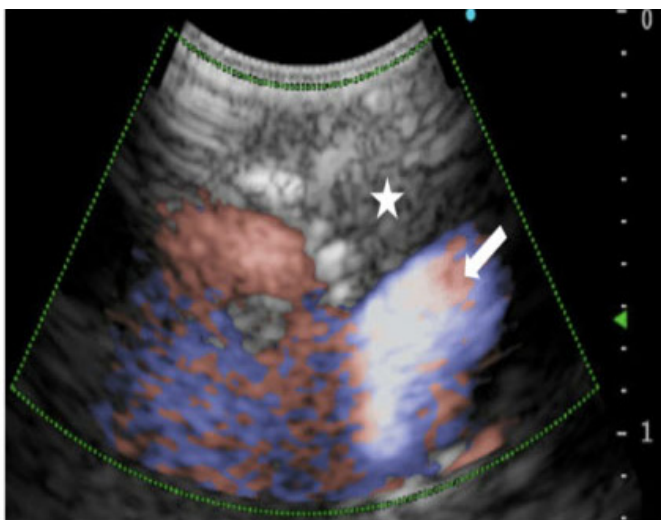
Bronchoscopic ultrasound and color-Doppler flow images of the broncholith. The broncholith (star) is seen as a hyperechoic structure invading into the segmental pulmonary artery (arrow) confirmed with color Doppler.
